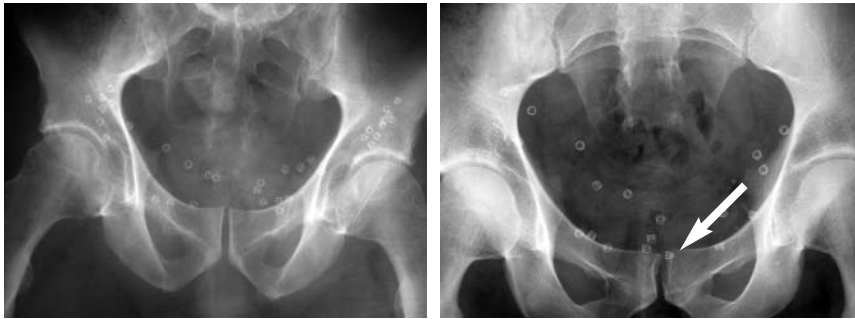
X-ray examples of patients who each had endoscopic bilateral hernia repair using plastic mesh and metal tacks to hold the mesh. These tacks may painfully impinge a nerve against a bone (arrow), or encircle the nerve beneath the skin.
